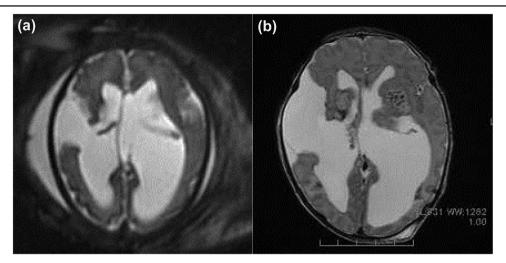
a Fetal brain magnetic resonance imaging (MRI) at 32 weeks of gestation. An axial half-Fourier-acquired single-shot turbo spin echo (HASTE) image shows ventriculomegaly and a large cleft in the right cerebral hemisphere. b Brain MRI on day 1. An axial T2-weighted image shows a large right hemispheric cleft lined by abnormal gray matter with ventriculomegaly. This is characteristic of schizencephaly
